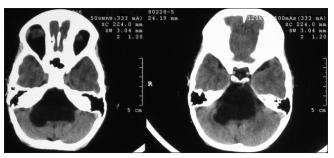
Computed tomography scan imaging demonstrating the epidermoid cyst which has reoccurred
